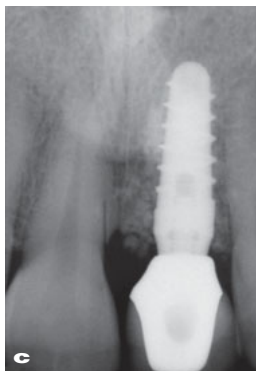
(a and b) Clinical, and (c) radiographic follow-up at T₁.
